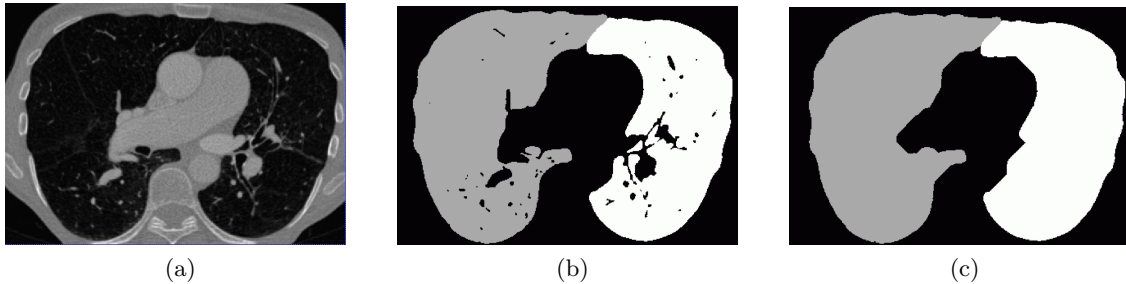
(a) CT image, axial slice, (b) coarse lung segmentation after separation, (c) refined lung segmentation.
